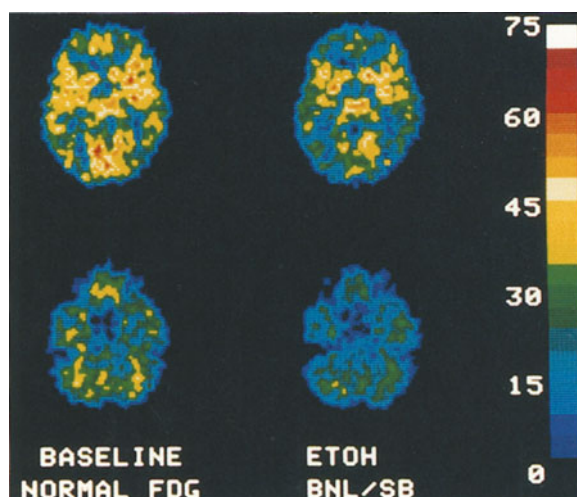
Brain metabolic images of a normal control at the level of the striatum and the cerebellum at baseline (left-side images) and during alcohol intoxication (right-side images). Notice the decrements in metabolism during alcohol intoxication. FDG, fluorodeoxyglucose; ETOH, ethyl alcohol
